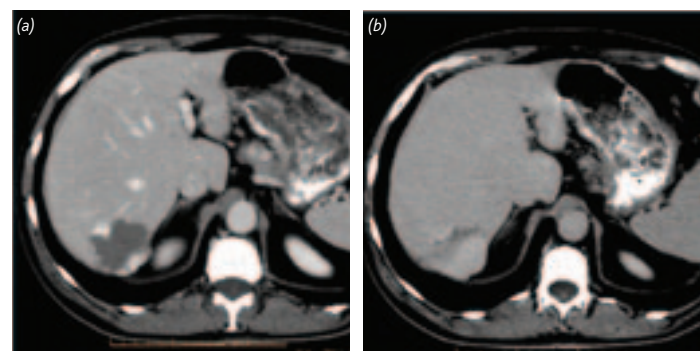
Haemokinetics of liver haemangioma by dynamic CT. (a) The hypodense lesion on the right liver lobe shows peripheral enhancement at the early phase of this study with (b) subsequent hyperdensity (retention) in the late phase
